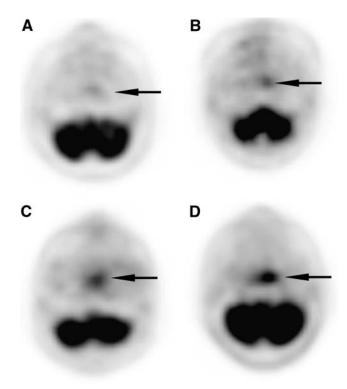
Categorization of level of uptake of ¹⁸F-FDG at primary site. (A) Mild accumulation of ¹⁸F-FDG (score of 1; arrow). (B) Equivocal increase in ¹⁸F-FDG accumulation (score of 2; arrow). (C) Probably abnormal increase in ¹⁸F-FDG uptake (score of 3; arrow). (D) Definitely abnormal accumulation of ¹⁸F-FDG (score of 4; arrow).
